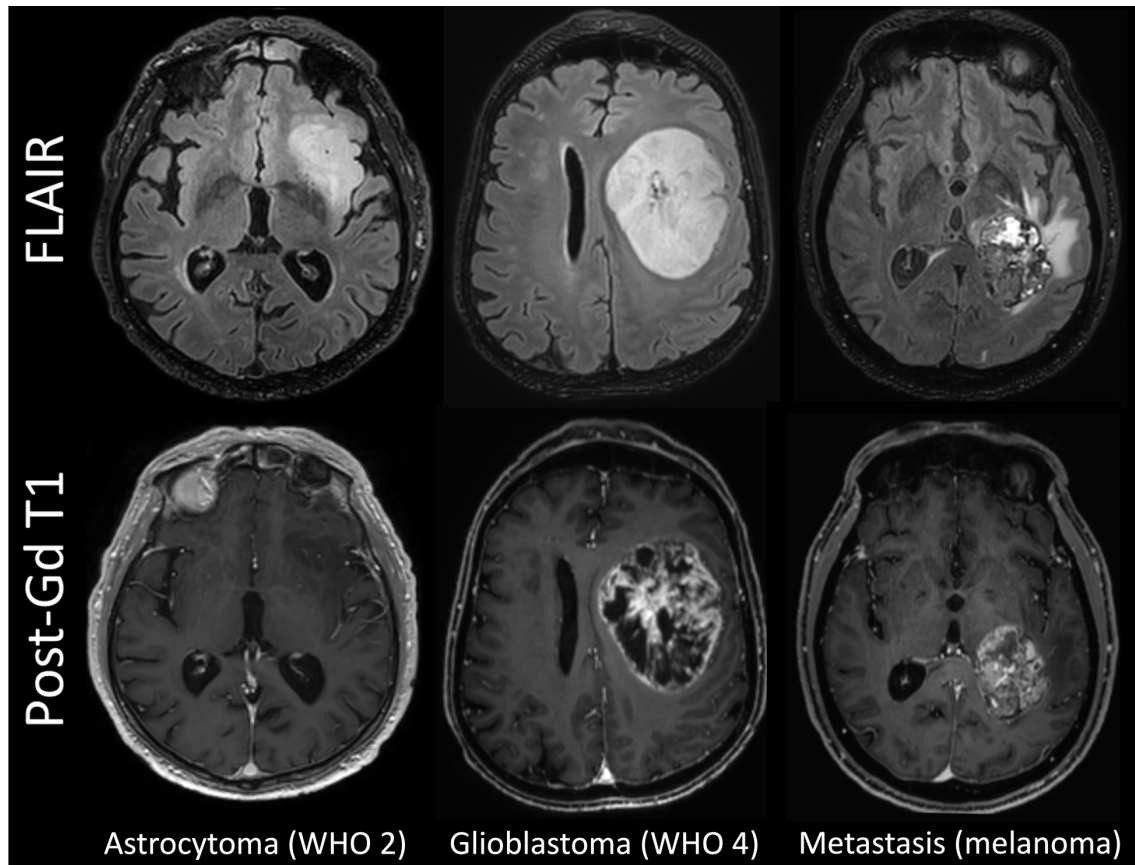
FLAIR and T1w images in representative cases
